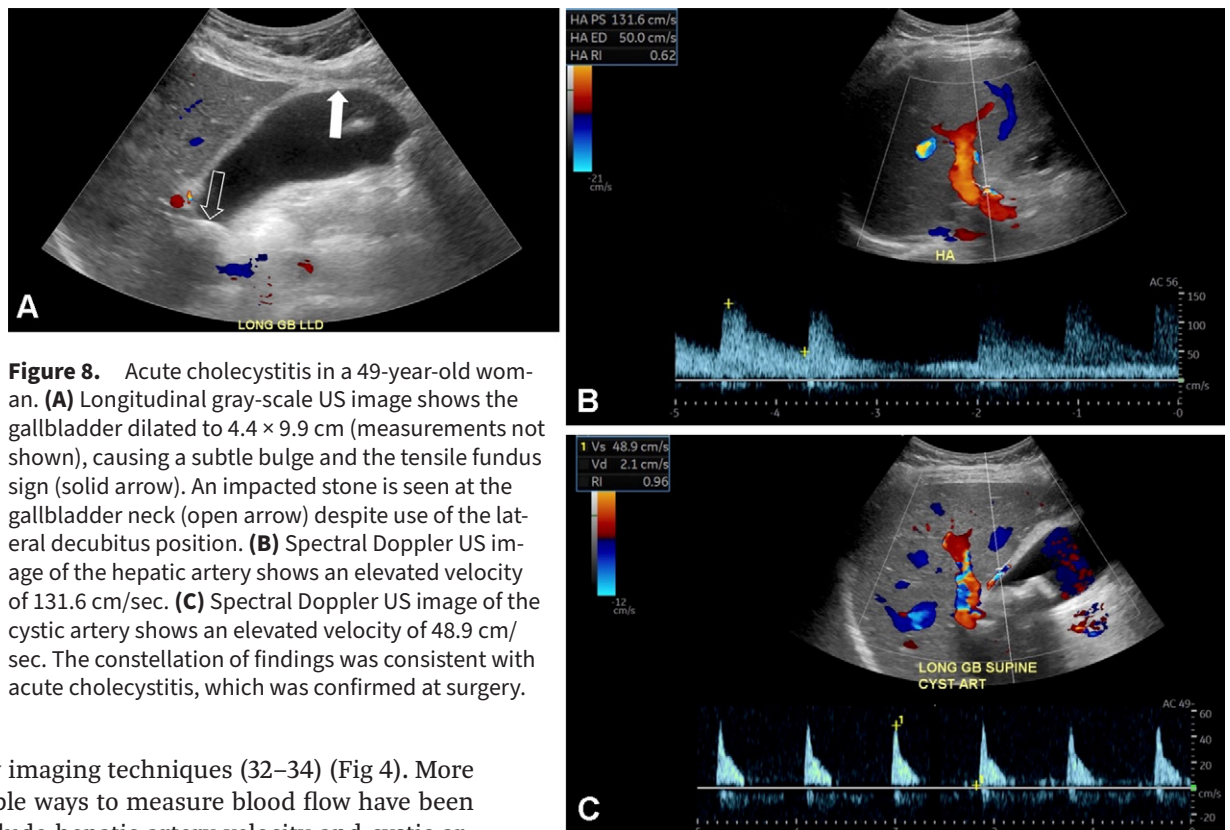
Acute cholecystitis in a 49-year-old woman. (A) Longitudinal gray-scale US image shows the gallbladder dilated to 4.4×9.9 cm (measurements not shown), causing a subtle bulge and the tensile fundus sign (solid arrow). An impacted stone is seen at the gallbladder neck (open arrow) despite use of the lateral decubitus position. (B) Spectral Doppler US image of the hepatic artery shows an elevated velocity of 131.6 cm/sec. (C) Spectral Doppler US image of the cystic artery shows an elevated velocity of 48.9 cm/sec. The constellation of findings was consistent with acute cholecystitis, which was confirmed at surgery.
